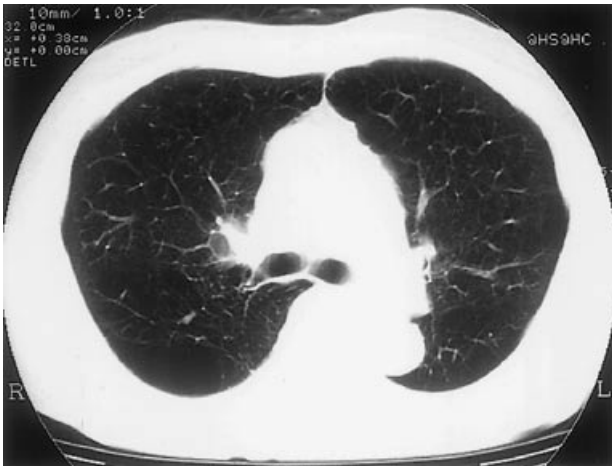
A chest CT film on admission. Multiple bulla formation and low attenuation area oriented in centrilobular and panlobular patterns in the bilateral lungs were seen. However, no abnormal nodular opacities and no hilar or mediastinal lymphadenopathy were detected.
